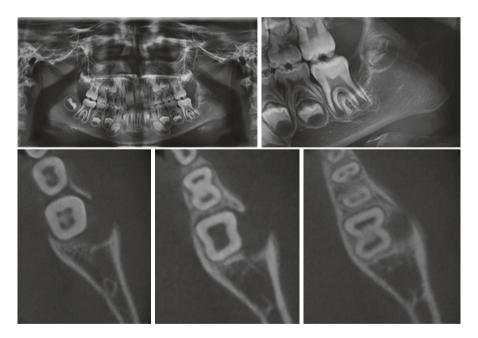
This is a cone beam computed tomography of a boy with cherubism. The top image shows the slices through the right-hand side of the mandible and maxilla, while the bottom images are slices through the left-hand side of both jaws. One can appreciate the missing molars in both jaws, and the multilocular lesions in the mandible, which have caused substantial expansion of the buccal and lingual contours of the mandible, especially on the patient's left-hand side
